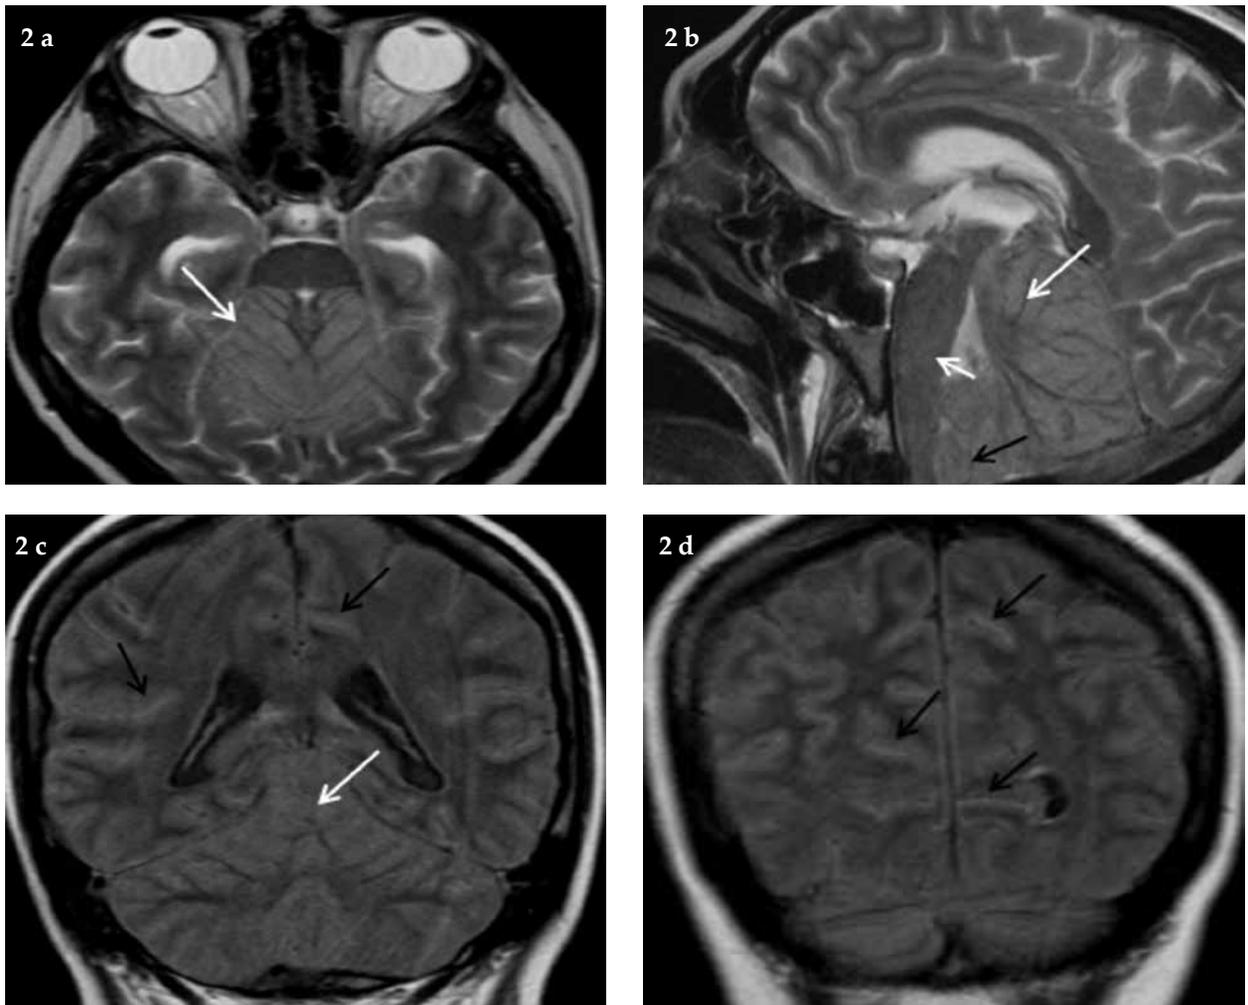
a,b,c,d) Precontrast brain MRI images showing diffuse hyperintensities of the tentorium and folia of cerebellum on T2W (a,b, White arrows) and FLAIR (c, white arrow) sequences. The linear cerebral leptomeningeal hyperintensities are also seen on the FLAIR images (c,d, black arrows). Note the compression of the brain stem (b, short white arrow) and the cerebellar tonsillar herniation (b, black arrow).
